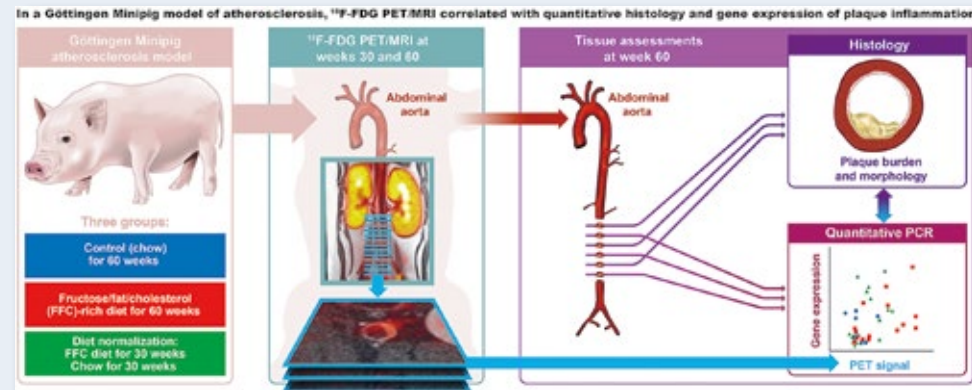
How we use a Göttingen Minipig model of atherosclerosis for non-invasive measurement of atherosclerosis by PET/MRI is longitudinal monitoring of therapies, e.g. GLP-1 analogues. The imaging findings of the model have been validated by tissue assessment at the end of the study. For further details on the model system, which we developed in collaboration with Novo Nordisk A/S, please see Ludvigsen TP et al. Atherosclerosis 2019.
